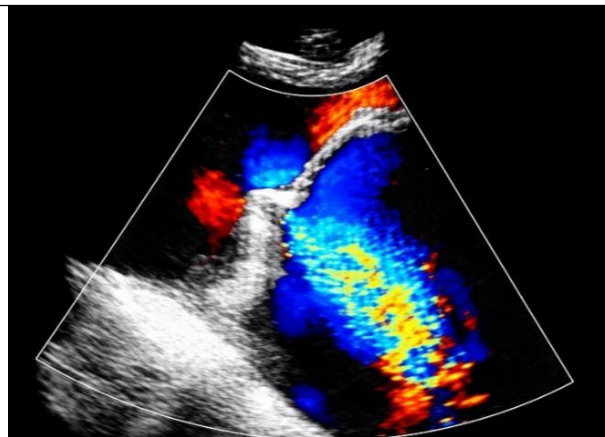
Color Doppler echocardiography demonstrating a severe eccentric posterolateral mitral regurgitant jet.
